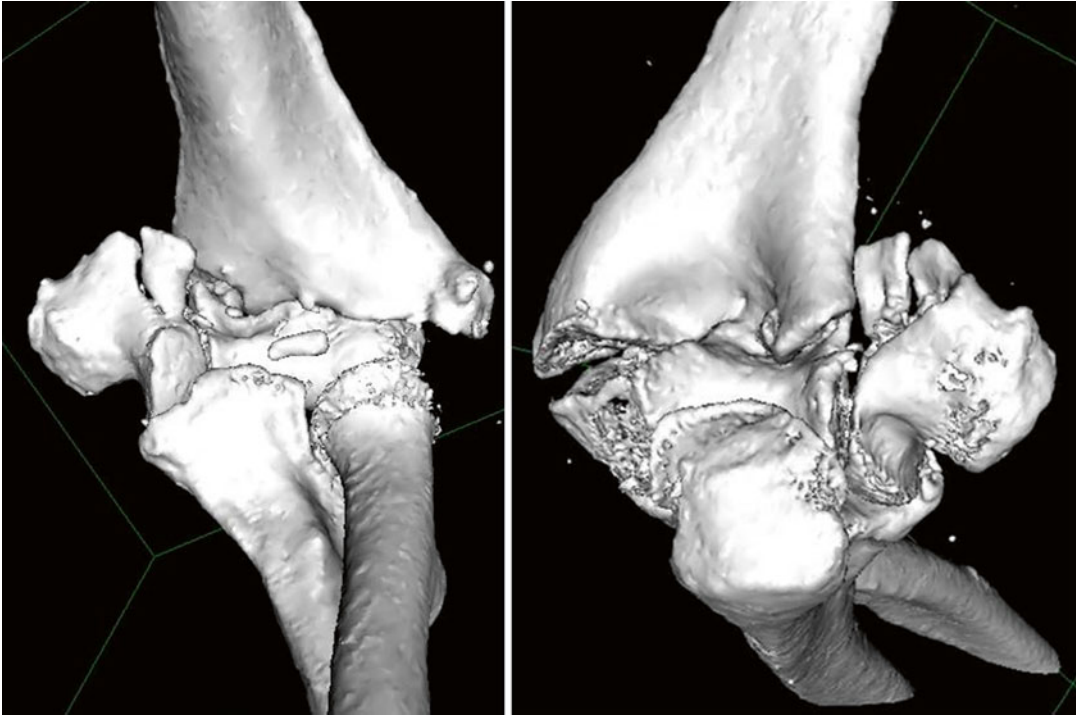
Distal humeral fracture 3D CT scan images (anterior and posterior visions)
